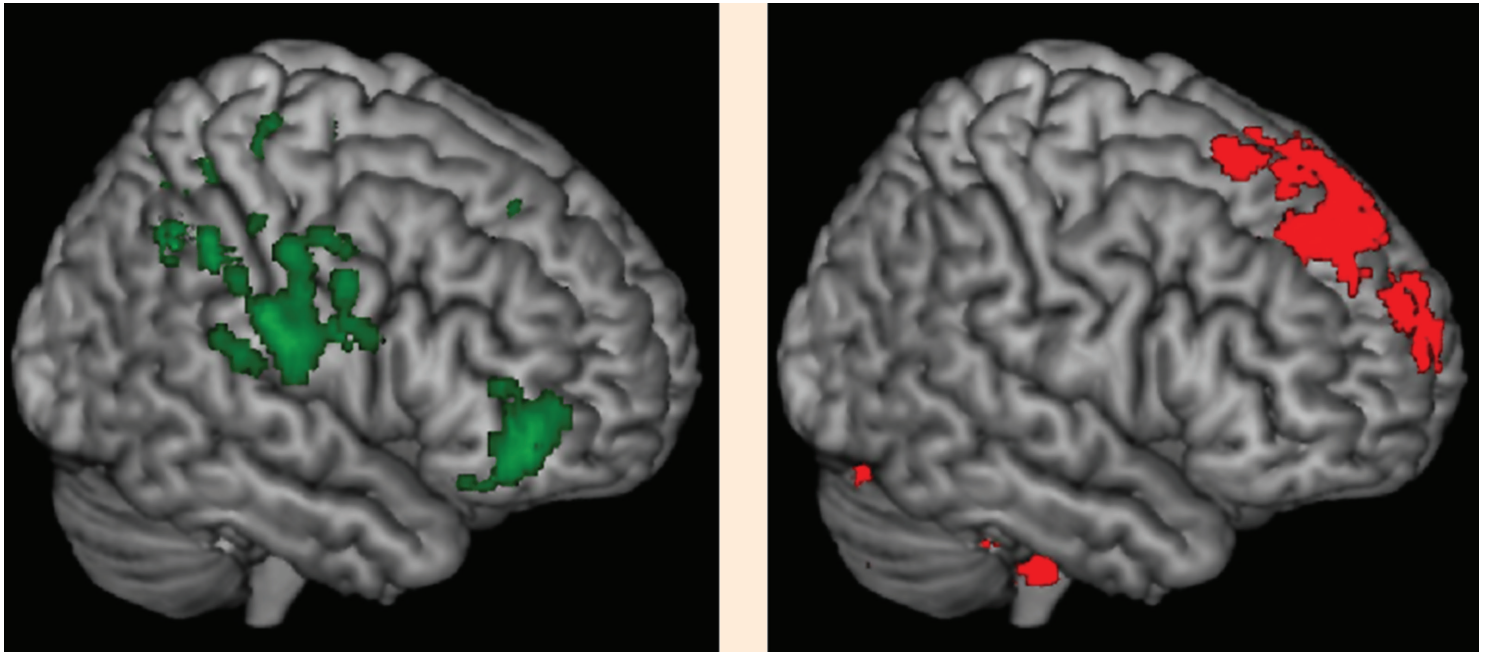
Functional magnetic resonance imaging during a task (pain), both in basal conditions without hypnosis (left panel) and during hypnotic analgesia (right panel). (5)
